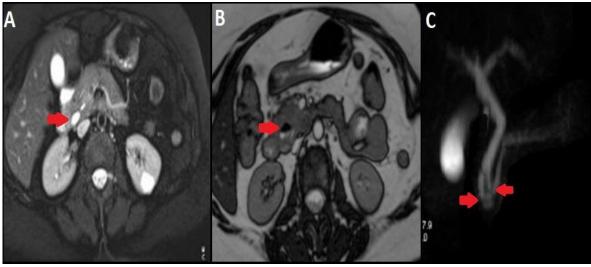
A) Magnetic resonance imaging of abdomen, T2 axial image shows dilatation of CBD B) Out of phase axial image showing the duodenal diverticulum anterior to CBD with air fluid level. C) MRCP shows close relationship of duodenal diverticulum to CBD.
